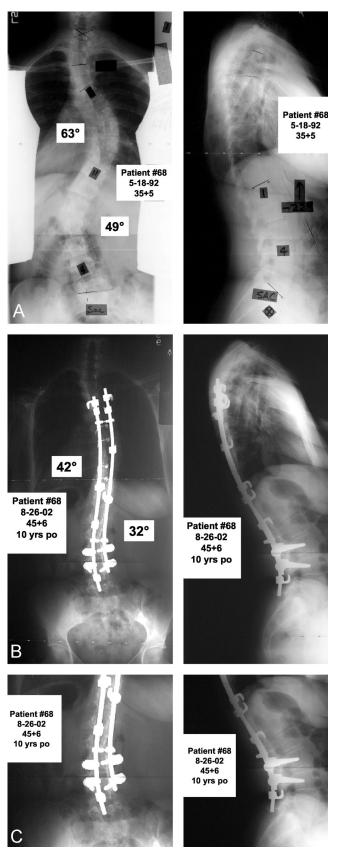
A, Standing long cassette coronal and sagittal radiographs before surgery. B, Standing long cassette coronal and sagittal radiographs 10 years postop. C, Coned down standing coronal and sagittal radiographs at ultimate follow-up. At this ultimate follow-up, the discs below (L4–L5 and L5–S1) still look very healthy.
